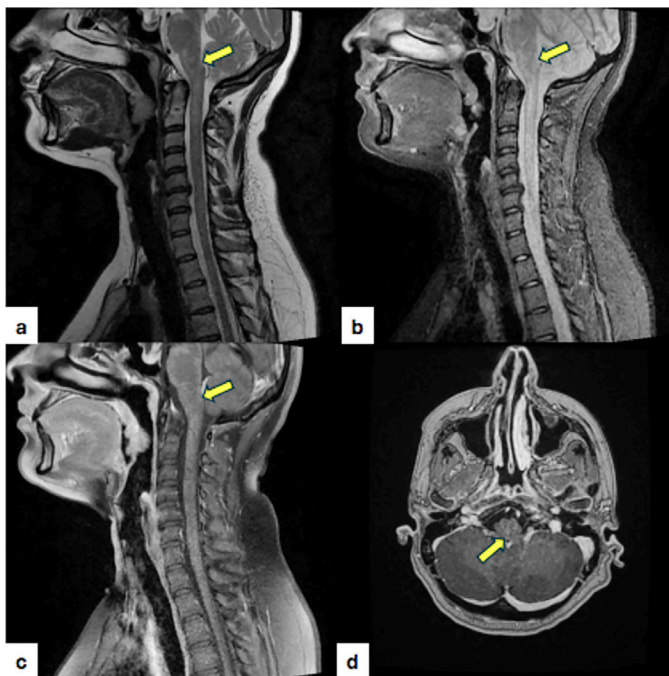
Sagittal T2 (a), short tau inversion recovery (b), post-contrast sagittal T1 (c), and axial T1 (d) MRI obtained with a 1.5-T scanner. These images reveal symmetric nodular-subpial enhancement along the cervical spine, as well as supratentorial meningeal and brainstem-cerebellum involvement, typical of neurosarcoidosis
